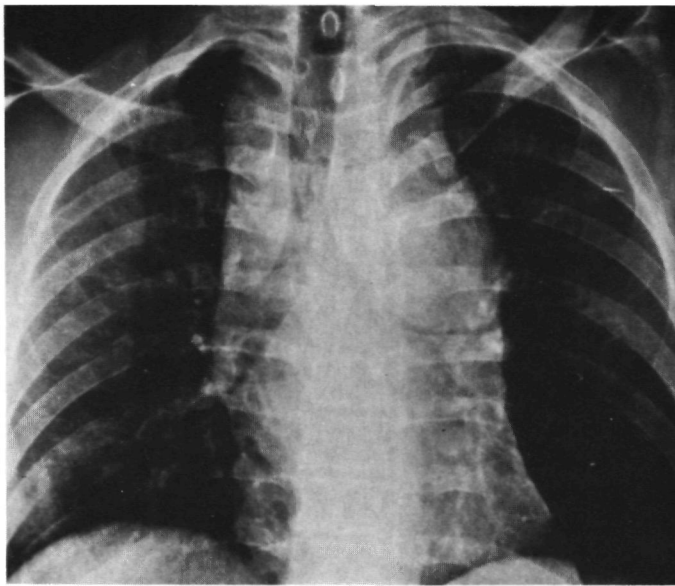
5 Male, 35 years, car-driver, TAR, uneventful recovery after operation. Chest X-ray: diffuse widening of the mediastinal shadow (12 cm) with sharp contours. Aortic knob not visible. Displacement of the trachea to the right. Widened paratracheal stripe. Normal paraspinal lines. Angiography: rupture of the aorta between the innominate artery and the right carotid artery (see also Fig.III.19b; same patient).
